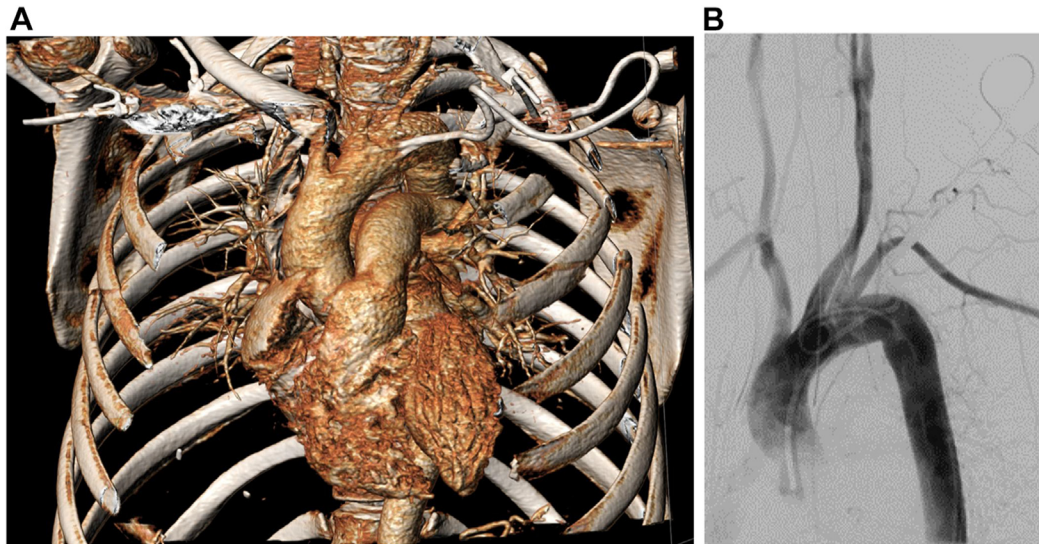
Preoperative volume-rendered three-dimensional computed tomography reconstruction (A) and intraoperative digital subtraction angiography (B) of aorta. The port catheter entered the distal aortic arch at the level of the outlet of the left subclavian artery (LSA) and left vertebral artery.
